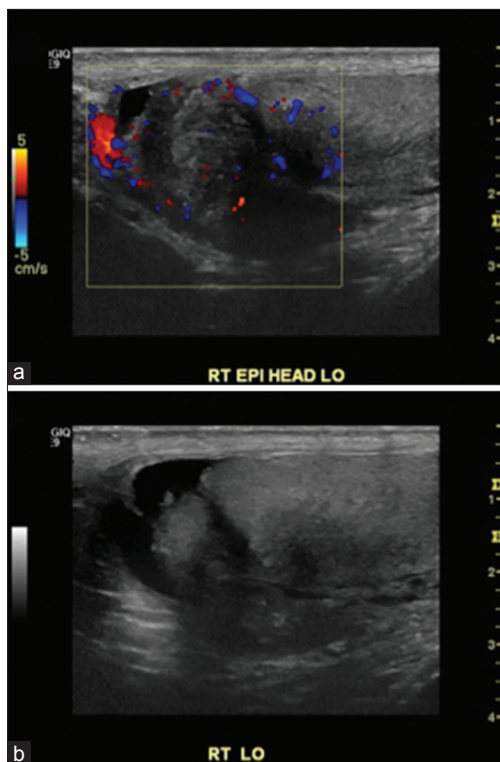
(a) Ultrasound image with color flow Doppler of enlarged mass in right epididymal head demonstrates increased vascularity with extension into adjacent testicular tissue. (b) B-mode ultrasound image of heterogeneous appearing mass within the right testicular mediastinum contiguous with heterogeneous appearing epididymal head mass
